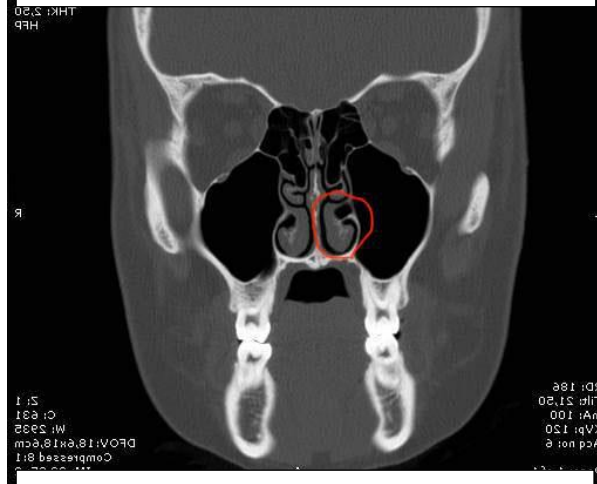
Paranasal sinus computed tomography image of the left inferior turbinate pneumatization. (Case 1, marked area)
